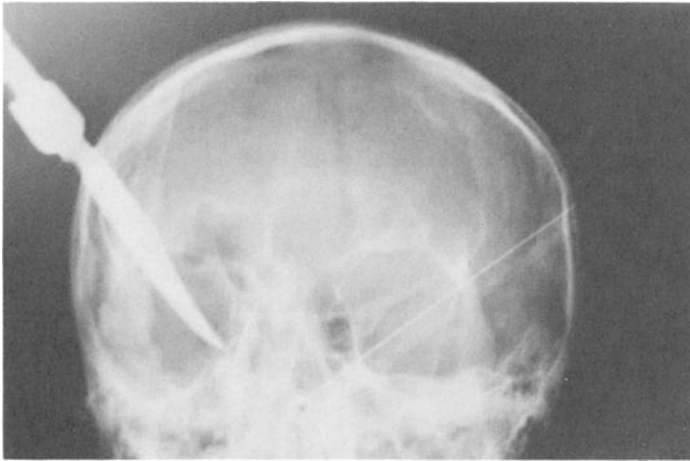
X-ray of the skull (anteroposterior view).
